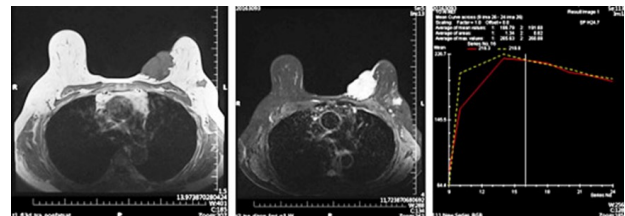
DCE-MRI findings in a patient (a 54-year-old woman).
